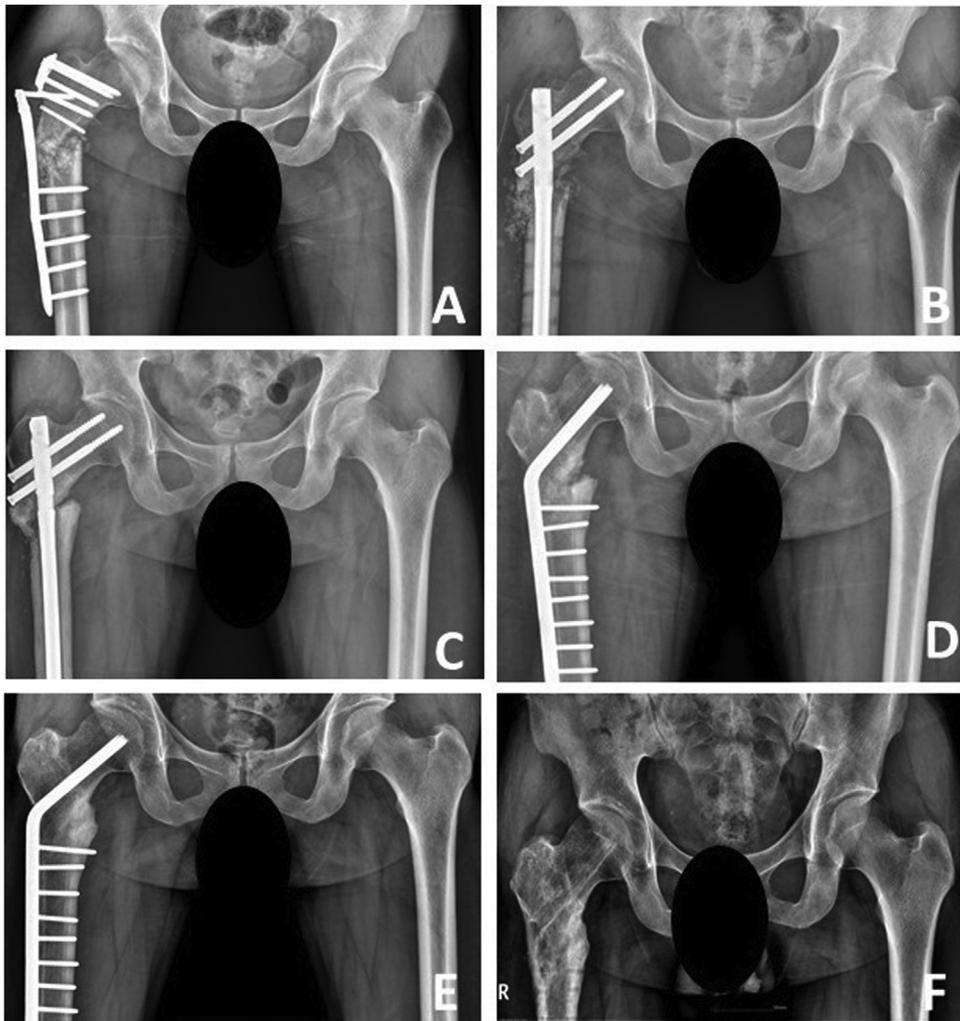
A 27-year-old man underwent valgus intertrochanteric osteotomy because of fixation failure of intertrochanteric fracture. (A) Radiograph obtained 6 months after fixation shows non-union of intertrochanteric fracture and fixation failure of the locking compression plate. (B) Radiograph obtained 2 weeks after re-fixation with intermedullary nail. (C) Radiograph obtained 11 months after re-fixation shows non-union of the intertrochanteric fracture. (D) Radiograph obtained 4 weeks after valgus intertrochanteric osteotomy shows restoration of the neck-shaft angle. (E) Radiograph obtained 2 years after osteotomy shows union at the osteotomy site. (F) Radiographs obtained 2 weeks after removal of implant shows complete bony union at the osteotomy site.
